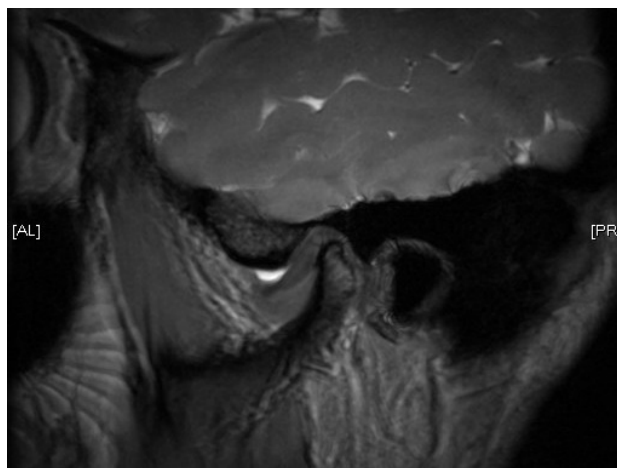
Sagittal sectional view of mouth-closed T2-weighted MRI shows anterior disc displacement with hyperintense joint effusion in superior synovial cavity.
